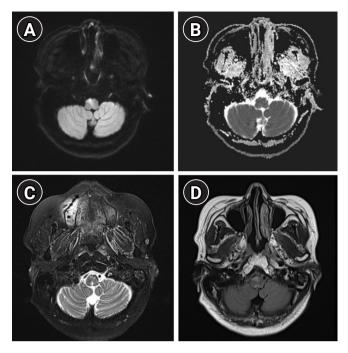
Magnetic resonance imaging (MRI) findings at admission. Baseline brain MRI revealing increased signals on the diffusion-weighted imaging sequence on the right anteromedial medulla (A) with a subtle signal change on apparent diffusion coefficient sequence (B) and increased signal intensity on T2-weighted (C) and T2-weighted fluid-attenuated inversion recovery (D) sequences.
